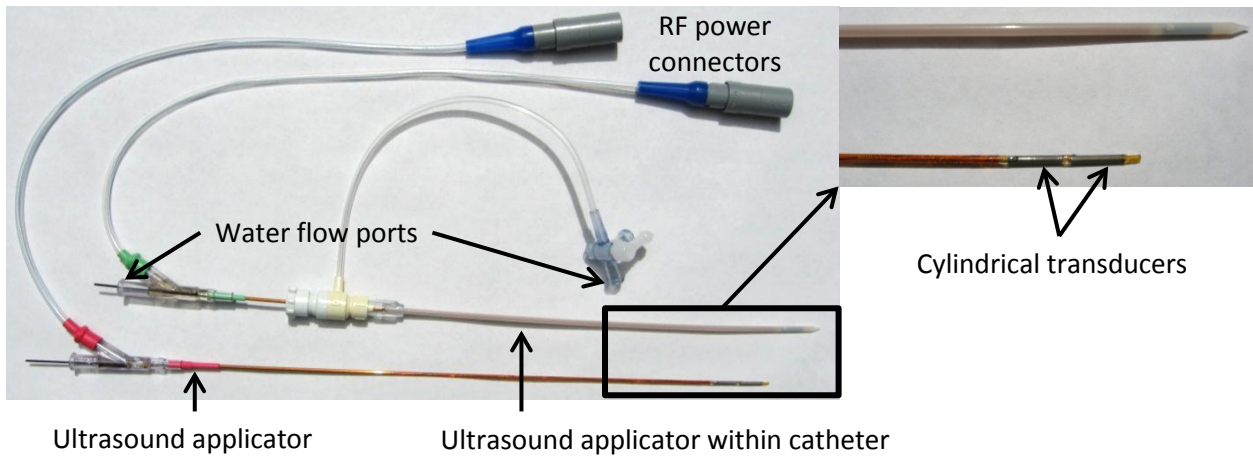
Interstitial ultrasound applicators with tubular transducers.
